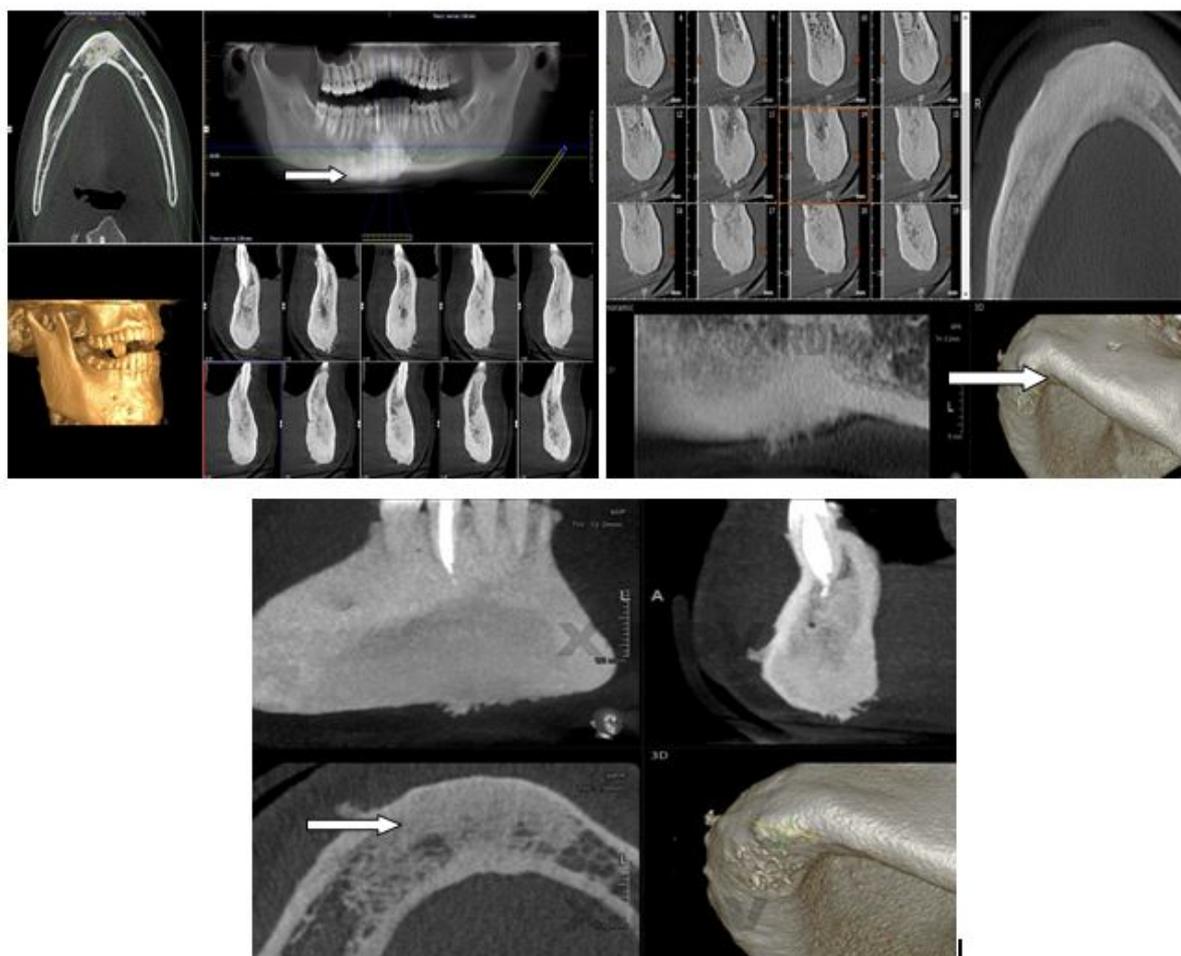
Series of 3D CT scans and computer modeling for surgery.
